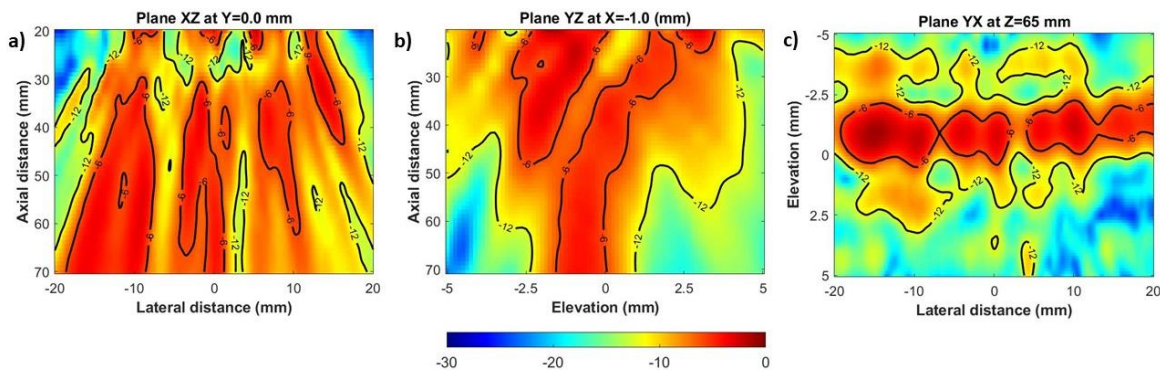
Intensity of the emitted ultrasound field a) in the XZ plane, b) in the YZ plane and c) in the YX plane. a) in the XY plane, at Y=0, the field is correctly diverging. Some destructive interferences can be visualized. b) in the YZ plane, the field is represented at X=1 mm because of a slight misalignment between the probe and the hydrophone. A large portion of the medium is insonified in elevation at shallow depth. This is due to the geometrical focus of the probe (65 mm) which makes the field converges in elevation. From 5 cm, the -6 dB insonified field covered around 1 mm in elevation. c) in the YZ plane, the field is represented at the geometrical focus, where the field is the narrower in elevation. At this depth, the medium is mostly insonified over a 1 mm range in elevation in front of the probe.
